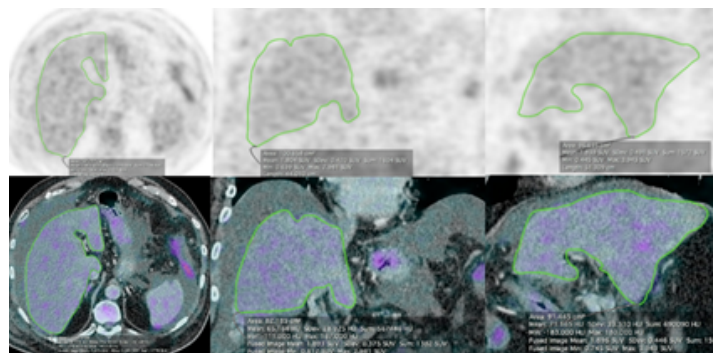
(A): MIP image of negative study scan showing no hypermetabolic lesions with abdominal distension "ascites. (B): shows total and functional hepatic volume of an advanced cirrhotic case with ascites, with 1252.2 and 1218.1 cc, respectively. (C): shows circular ROI within the aortic arch on axial PET and fused PET/CT images, with SUVmean ~1.4.
